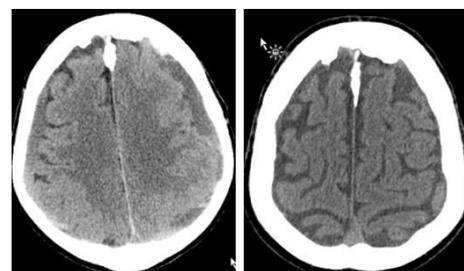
Left: Non-contrast CT head on initial presentation, demonstrating bilateral CSDH with minimal sulcal effacement and compression. Right: Non-contrast CT head at last follow up, demonstrating complete resolution.
